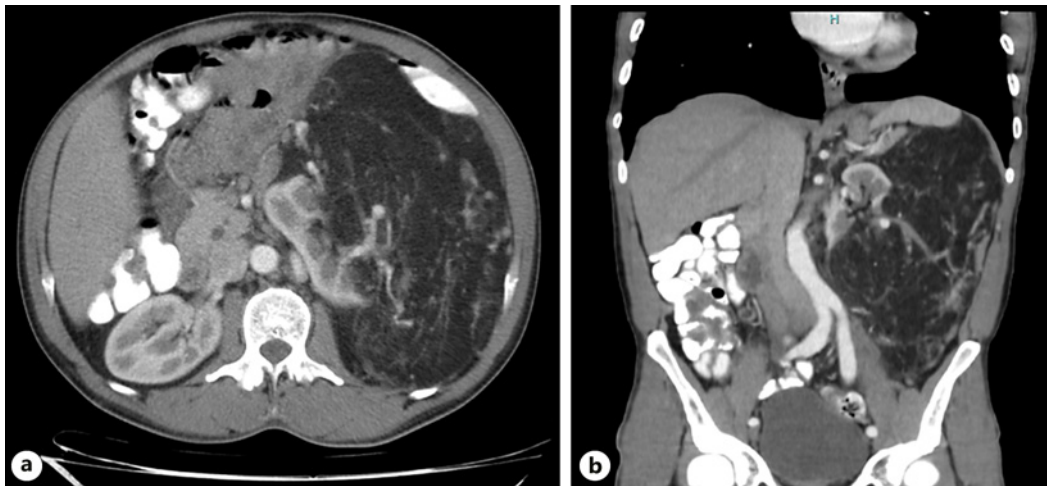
a, b Abdominal computed tomography (CT) scan showing a retroperitoneal tumor lesion with adipose density and vascular tracts, approximately 24 × 21 × 20 cm, causing displacement of adjacent organs.
